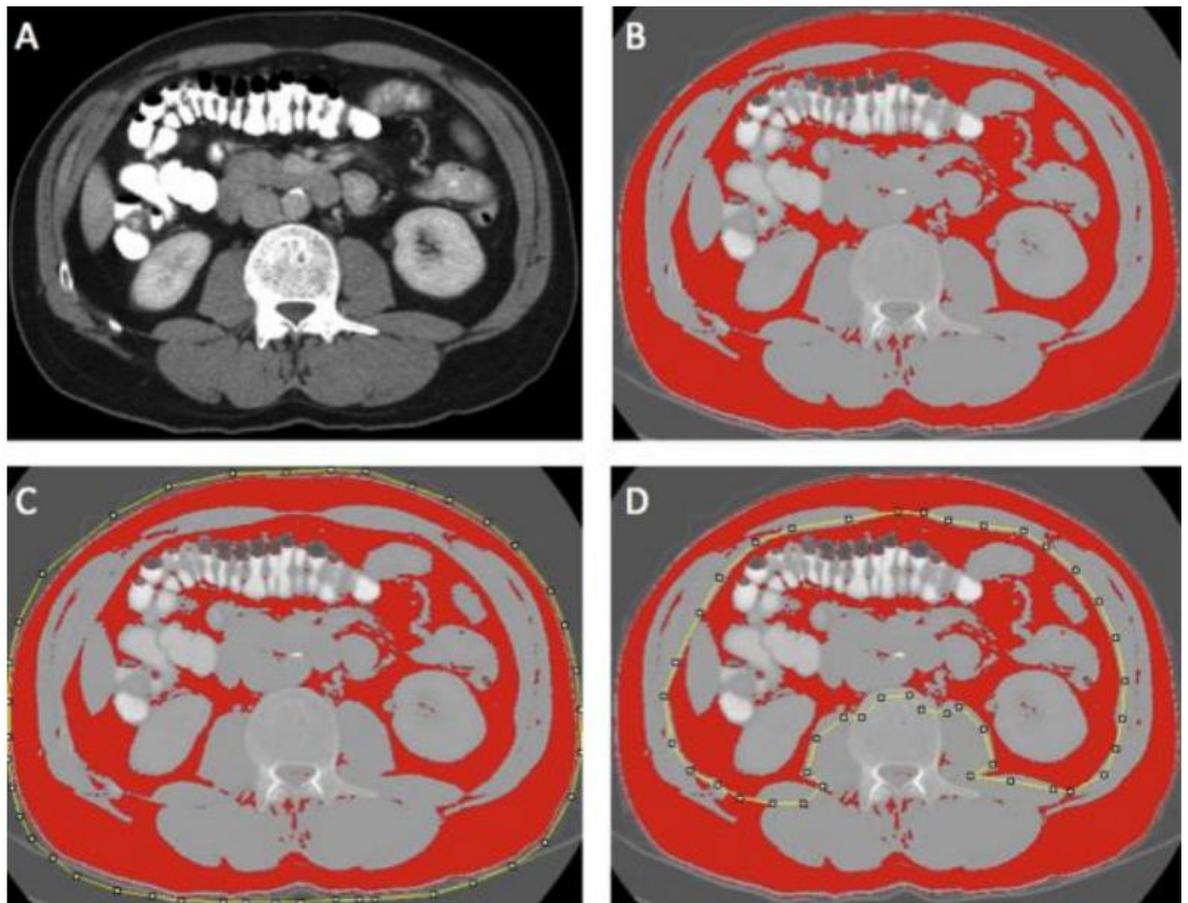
The use of ImageJ for analysis of total/visceral fat area (A) Axial CT slice at L3 level in portal venous phase, (B) Threshold selection of adipose tissue, (C) Region of interest selection for total fat area, (D) Region of interest selection for visceral fat area
